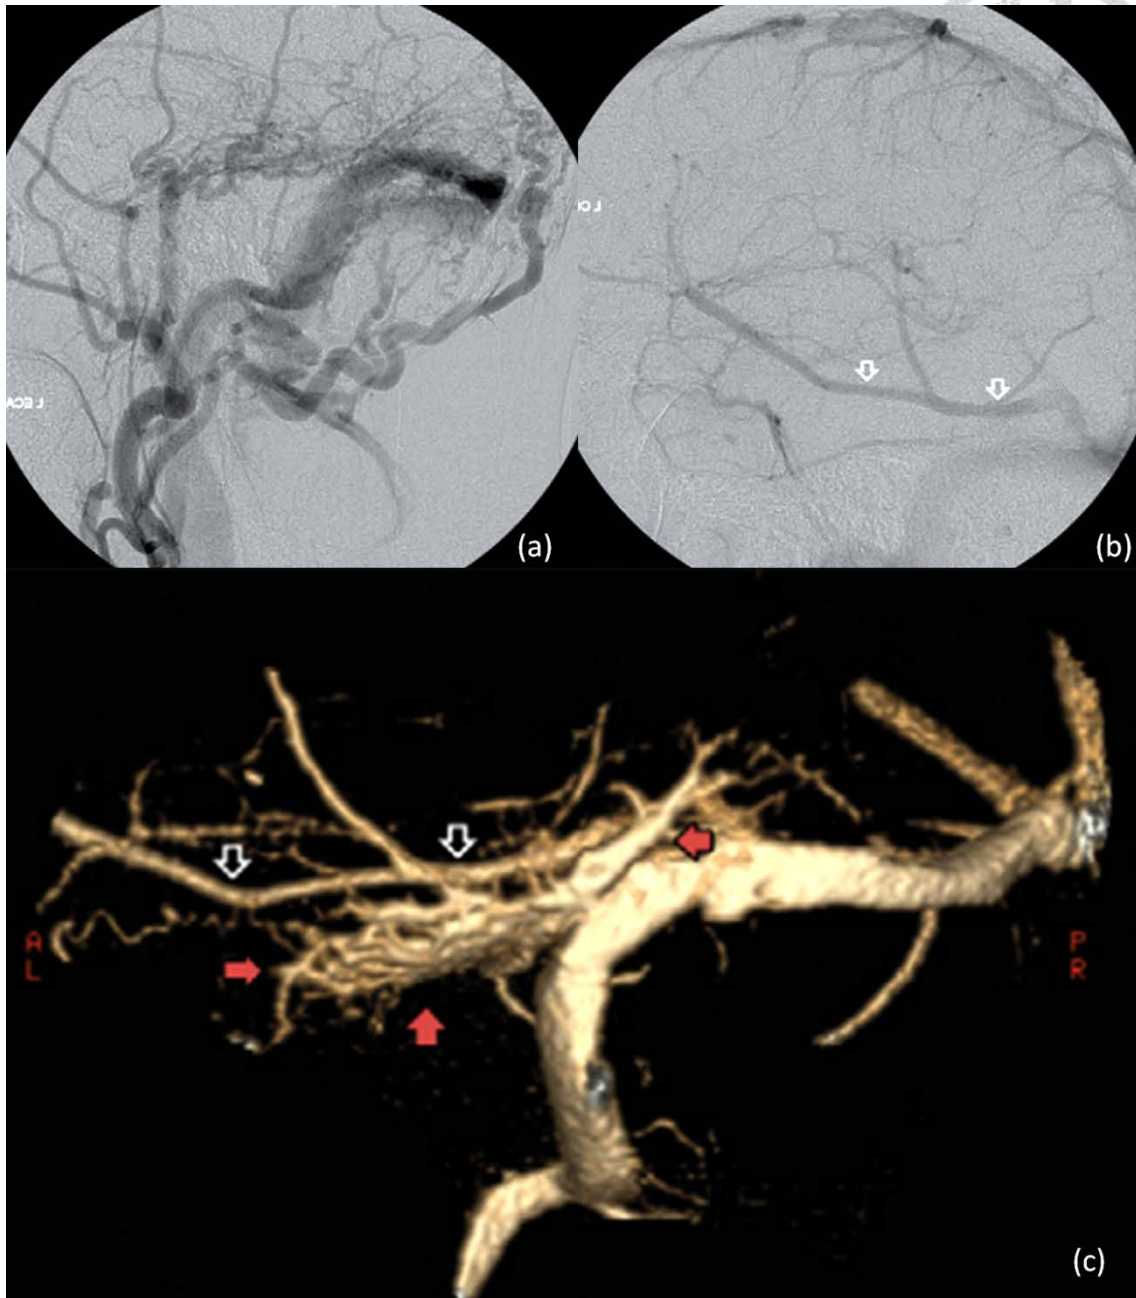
Patient 13. Images in 60-year-old man with pulsatile tinnitus. (a) Lateral projection of left external carotid artery demonstrates a type IIA dural AVF (Cognard et al [4] classification) at the left transverse-sigmoid sinus area. (b) Left common carotid artery angiogram obtained in the venous phase shows the left vein of Labbé (arrows) also draining into the left transverse sinus. (c) Hybrid CT angiogram obtained with volume rendering shows the fistula (red arrows) actually located at the dura next to the sigmoid sinus. The vein of Labbé (open arrows) is next to the fistula and drains into the transverse sinus.
